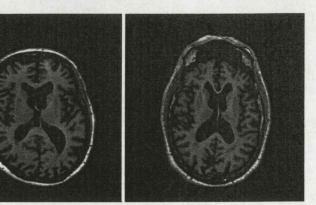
T1-weighted brain MRI from two different subjects.
